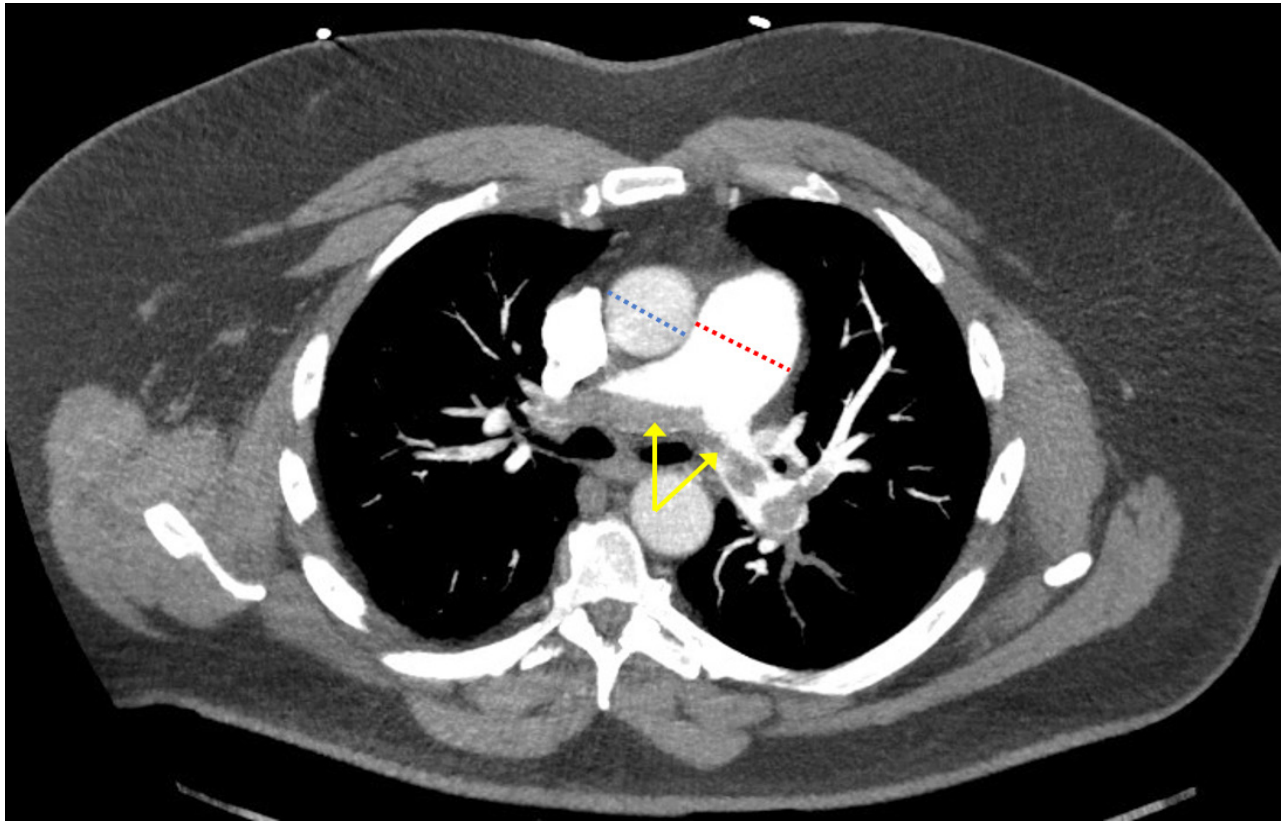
Computed tomography pulmonary angiogram demonstrating a saddle embolism at the main pulmonary artery bifurcation extending into right and left pulmonary arteries (yellow arrows). Also visible is an enlarged main pulmonary artery diameter (red dashed line) relative to the ascending aorta (blue dashed line) indicating right-sided heart strain with pulmonary hypertension.
